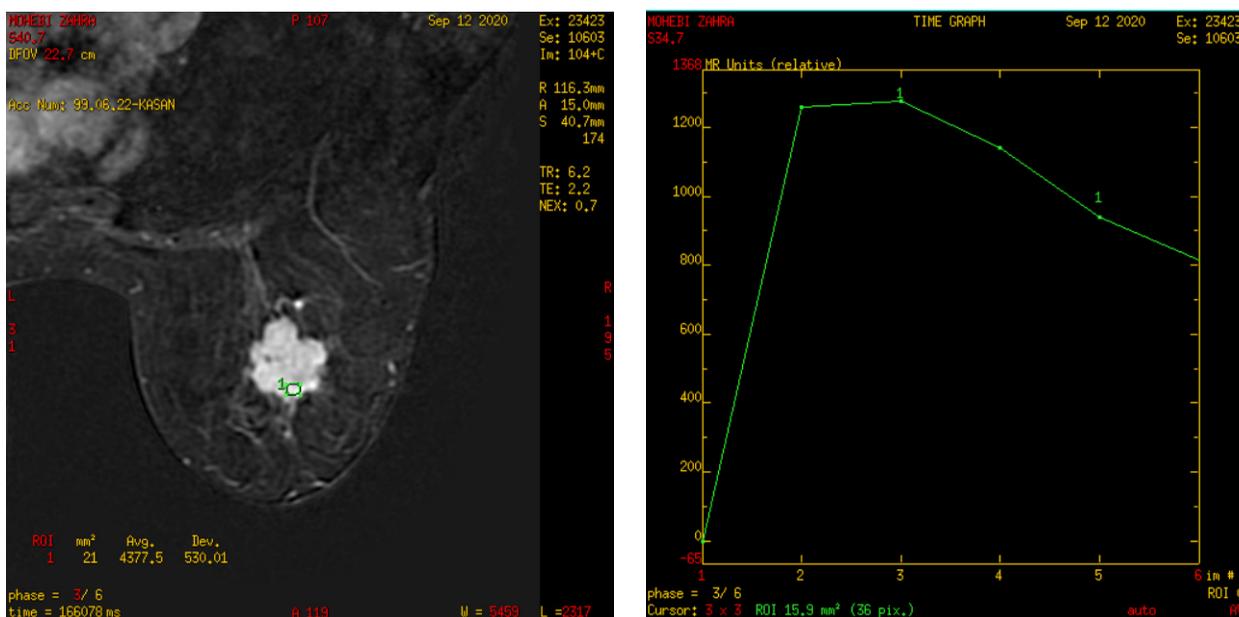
DCE-MRI and time-signal intensity curve: left breast lesion.
